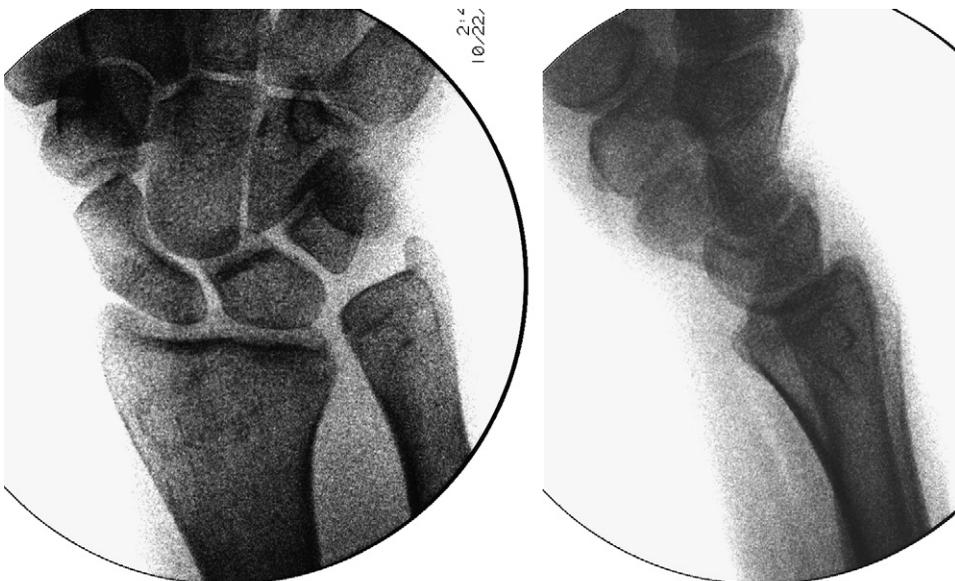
Preoperative radiographs of a chronically unstable DRUJ after radial head resection for a congenitally dislocated radial head with deformity of the distal ulna. (Courtesy of Joseph F. Slade III, MD, New Haven, CT.)
